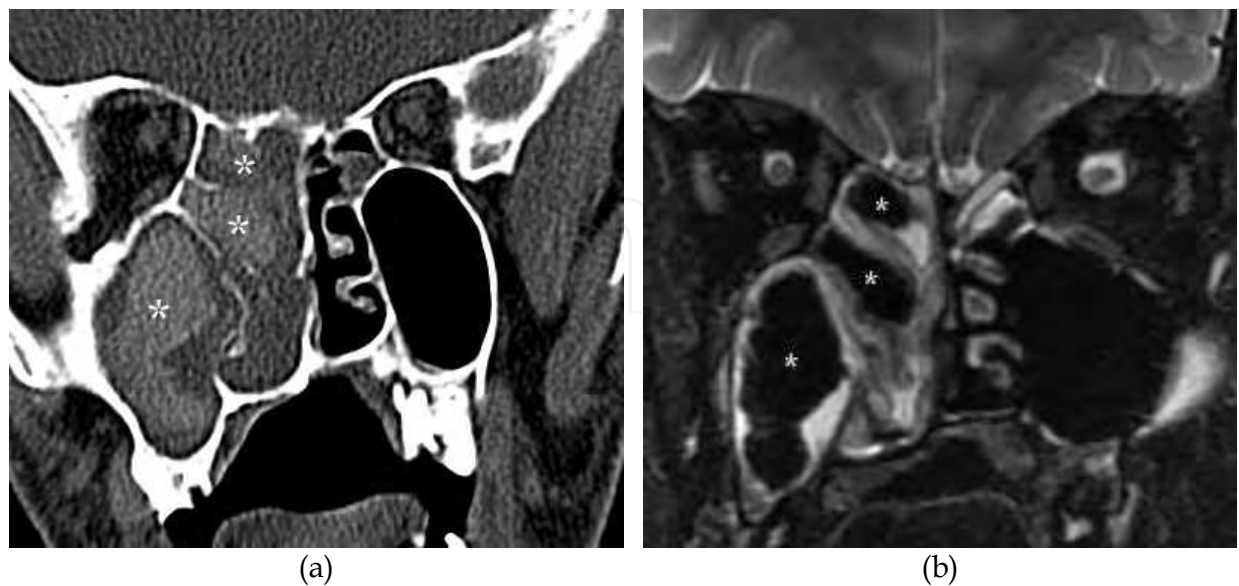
(a) Coronal CT shows total opacification of ipsilateral maxillary and ethmoid sinuses as well as the nasal cavity. The high density of the opacifications (asterisks) are a typical finding in allergic fungal sinusitis. (b) Coronal MR with STIR sequence shows signal void (asterisks) corresponding to the high density at CT. Courtesy A. ElBeltagi, Kuwait.
